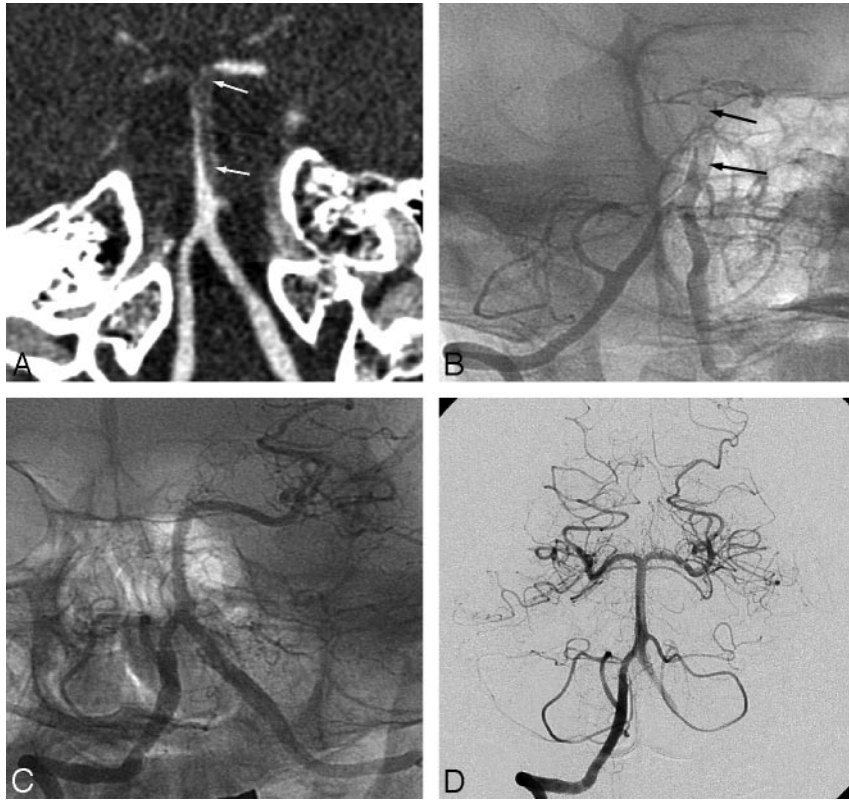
A 42-year-old man presenting with progressive deterioration of consciousness. CT angiogram (A) and vertebral angiogram (B) reveal near-occlusion of the basilar artery by an intramural hematoma (arrows). C, After emergency stent insertion, the basilar artery and left posterior cerebral artery are visualized, but the right posterior cerebral artery is not seen on vertebral angiogram. D, A 2-week (not seen) and 18-month follow-up vertebral angiogram show a patent basilar artery and its branches. The patient had a favorable outcome (mRS score, 0).
